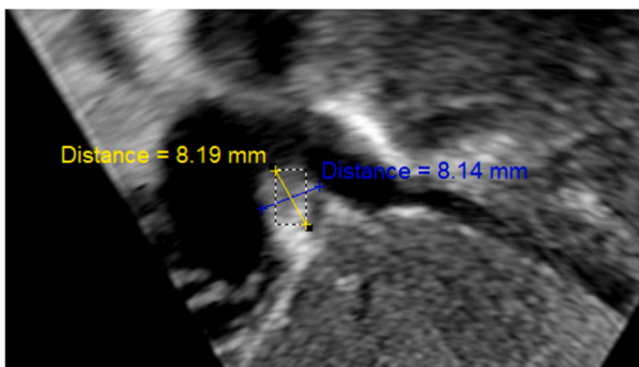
Subcostal view of Transthoracic echocardiography showing an 8.19×8.14 mm right atrial mass after three months of treatment.
